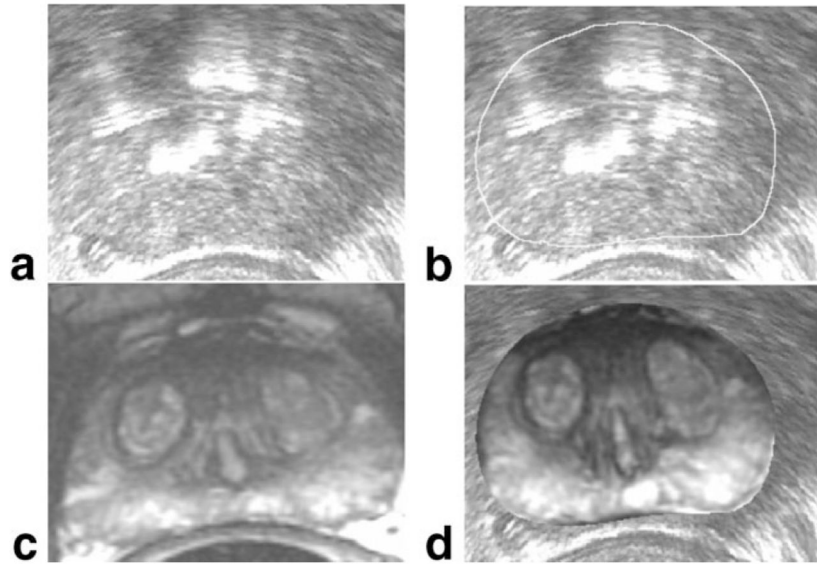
MR to ultrasound registration for brachytherapy treatment planning. Similar to the case shown in Fig. 10, intraoperative axial ultrasound imaging of the prostate (a) is manually contoured (b) to delineate the glandular boundary. Preoperative 1.5T T2-weighted axial MR imaging (c), obtained with an endorectal coil, is registered to the contoured capsule to produce an integrated view of preoperative imaging within the intraoperative imaging space (d).
